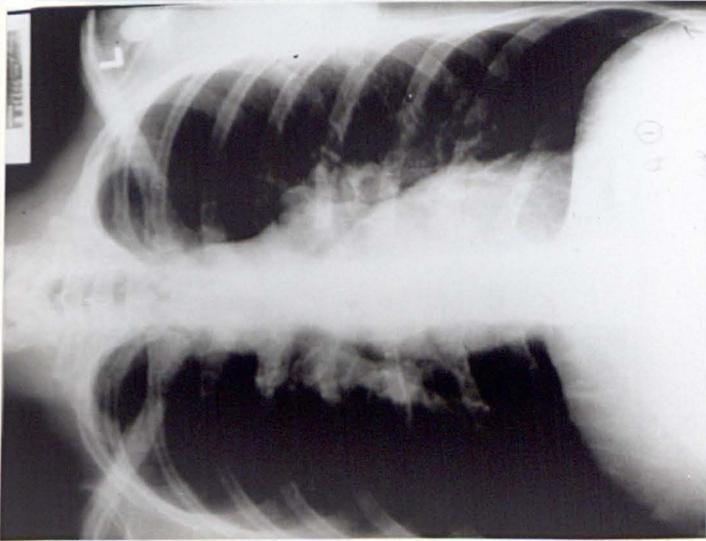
(vii). Normal chest X-ray.
